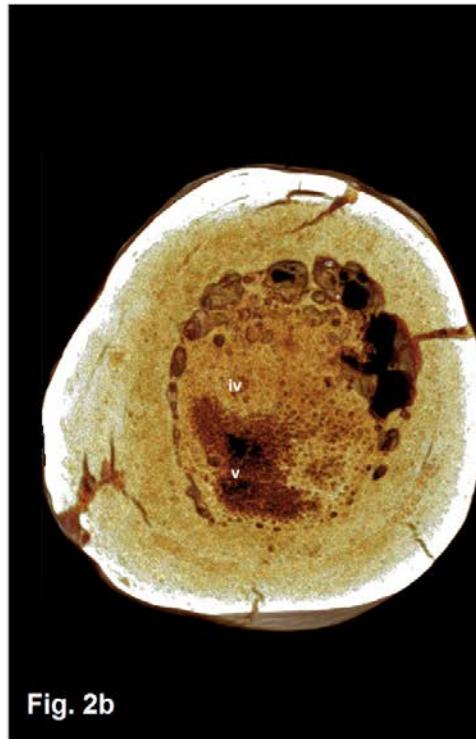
Fragment of a right rib of a large dinosaur, *Apatosaurus* sp. (a), which presents a sub-rounded mass with multilobulated surface (c), and high radiographic density (b) (Jurassic, Wyoming, USA; sample 323 of the University Museum, Chieti).
